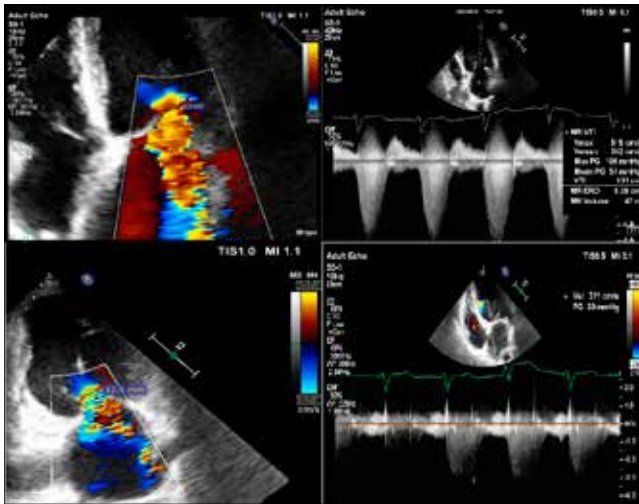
Transthoracic echocardiography. Semiquantitative and quantitative assessment of severity of mitral regurgitation. Vena contracta width 9–12 mm (apical views), effective regurgitant orifice area 0.38 cm², regurgitant volume 47 ml. Tricuspid regurgitation peak velocity 3.1 m/s
